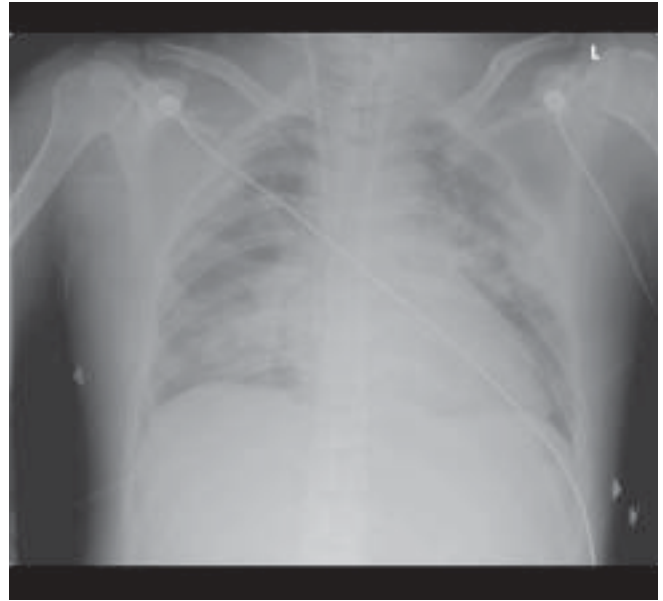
Chest x-ray after surgical debridement demonstrating diffuse airspace opacities consistent with a pattern of acute lung injury.
